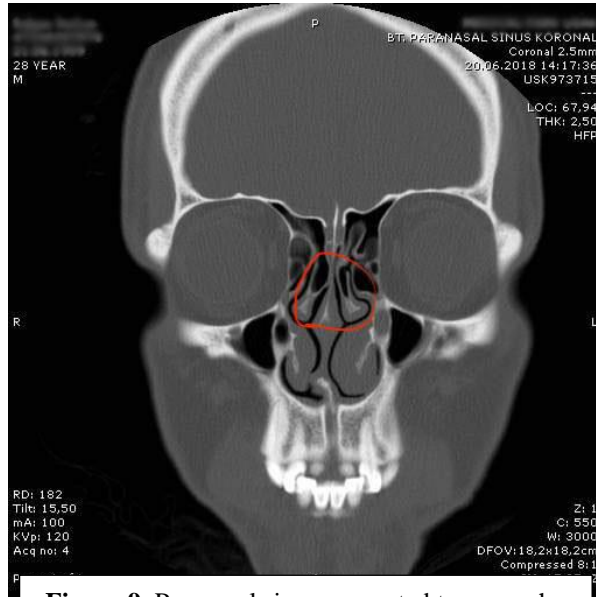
Paranasal sinus computed tomography image of bilateral middle turbinate pneumatization. (marked area)
